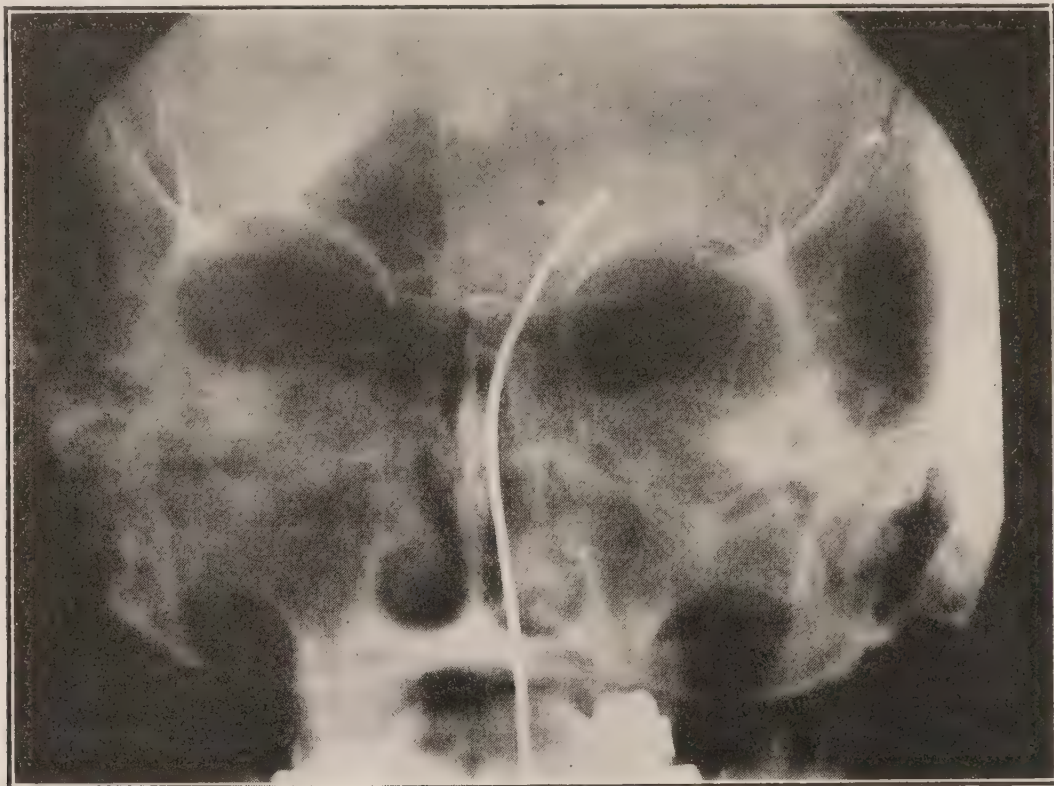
X-ray of the nasal accessory sinuses, showing disease in the left frontal and ethmoidal cells. The probe is in the frontal sinus.
